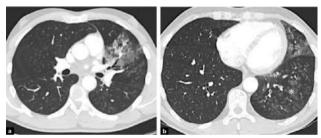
(a) Axial CT shows focal alveolar changes (stars) surrounded by a ground-glass opacity in the linguistic lobe suggesting hemorrhage in that region. (b) Axial CT at the level of the lung bases depicts a nodular ground-glass opacity (star) in the inferior lobe of the left lung, indicating an extension of hemoptysis to the inferior lobe.¹
